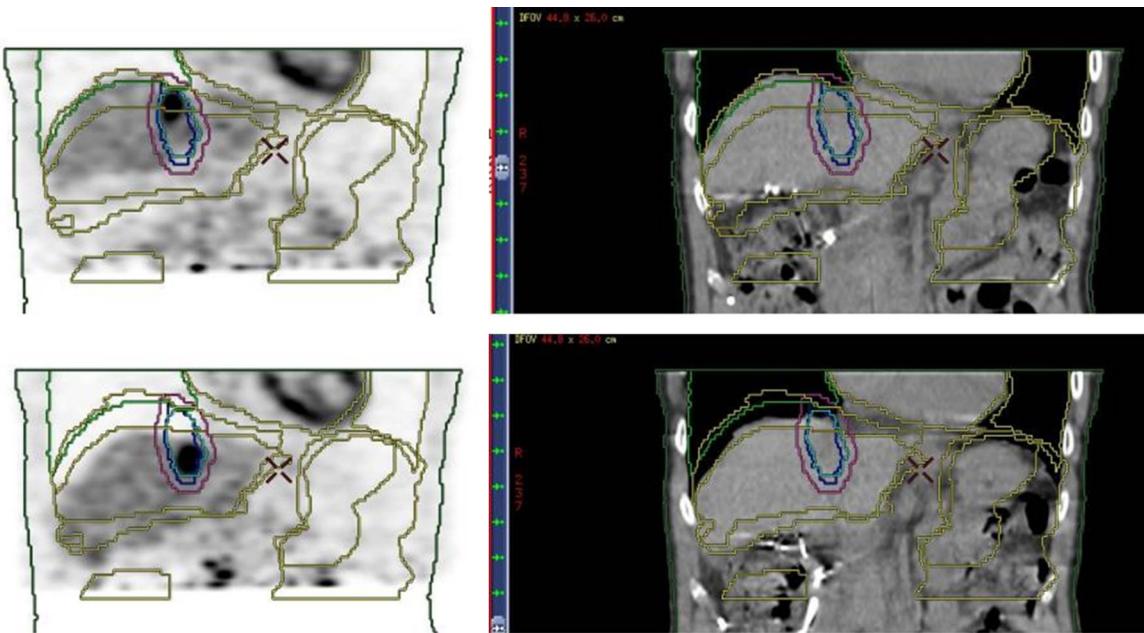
Coronal view of 4D CT (right side) and 4D PET CT (left side) in end expiratory (upper part) and end inspiratory (lower part) phases in a patient with liver met referred for SBRT. The respiratory cycle of the patient is divided in ten phases acquired for 4D CT and 4D PET CT. The volume is set by contouring each one of the ten phases and overlaps the contours to create an internal target volume. Only the end expiratory and end inspiratory phases of these ten phases are shown.
